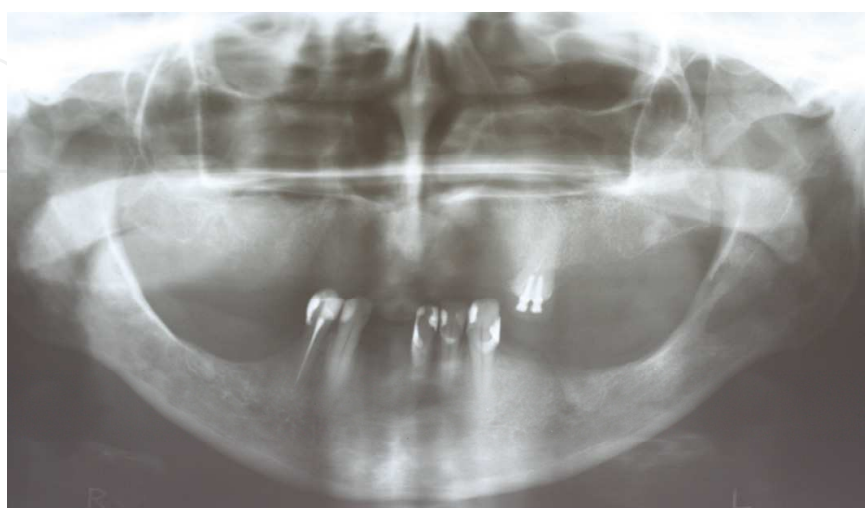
Follow-up X-ray examination reveals progression of the bone resorption
